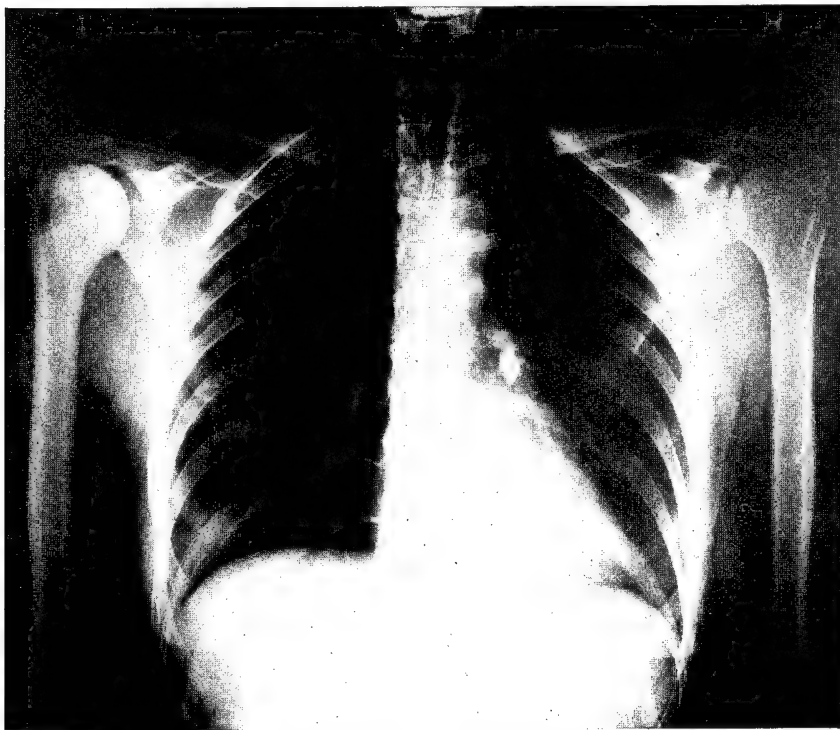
Roentgenogram showing involvement of the proximal half of the right humerus. Note the cystic area in the head of the humerus and thickening of the cortex of the proximal half of the shaft, with narrowing of the medullary canal.
